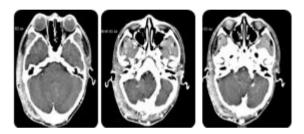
Focused mastoid CT scan with contrast
